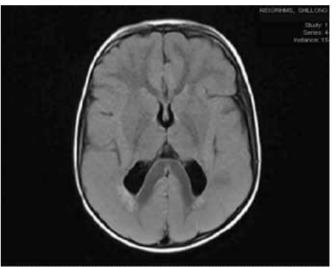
Photograph of MRI, showing lissencephaly with Pachygyria more prominent in parieto-occipital and temporal regions
